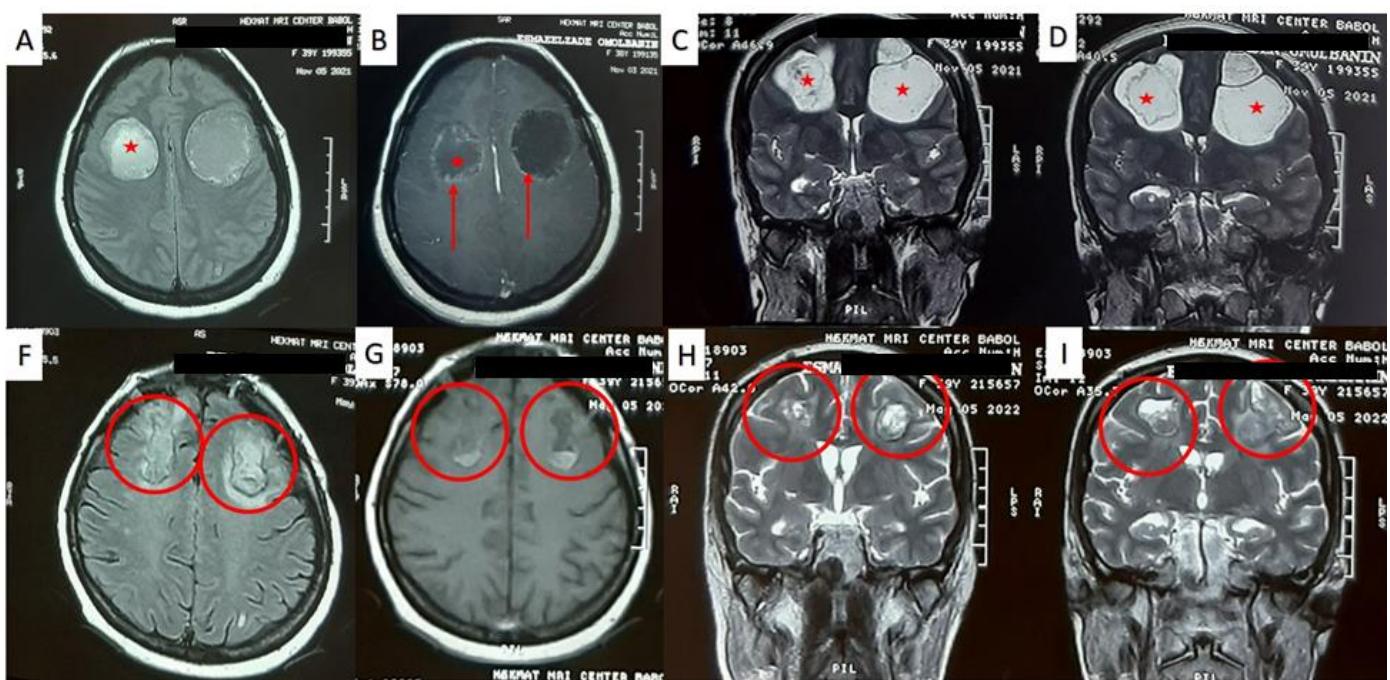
Magnetic resonance imaging of the patient. A-D) Pre-treatment brain MRI, A, and B show T2-weighted axial scan, T1-weighted with gadolinium (Gd) axial scan, respectively; C and D depict T2-weighted coronal scans. F-I) Post-treatment brain MRI (on one-year follow-up), F and G show T2-weighted axial scan, T1-weighted with Gd axial scan, C and D depict T2-weighted coronal scans, respectively; H and I represent T2-weighted coronal scans. Stars show the cystic lesions, arrows point to the rim enhancement area, and circles depict the post-treatment area of previous cystic lesions.
